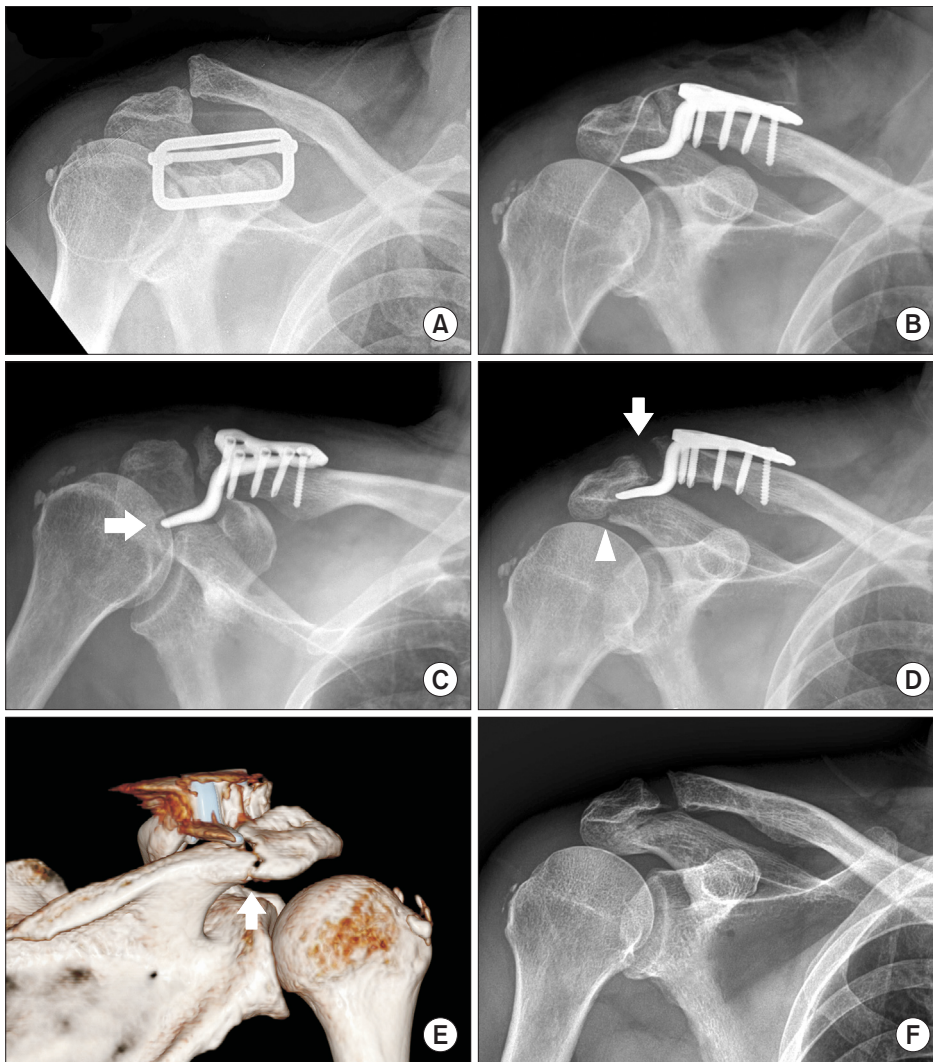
(A) The clavicle anteroposterior view showing acromioclavicular joint dislocation of Rockwood type V. (B) Immediate postoperative radiograph showing acceptable reduction and internal fixation with locking compression plate clavicle hook plate. (C) At postoperative 4 weeks, radiography showing erosion (arrow) around the hook of the plate. (D) At postoperative 10 weeks, radiography showing fracture of the acromion (arrowhead) and dislocation of the acromioclavicular joint (arrow). (E) At postoperative 10 weeks, 3-dimensional computed tomography showing fracture of the acromion (arrow) and unhooking of the plate. (F) The radiography obtained 15 months after the initial surgery showing solid union of acromion.
